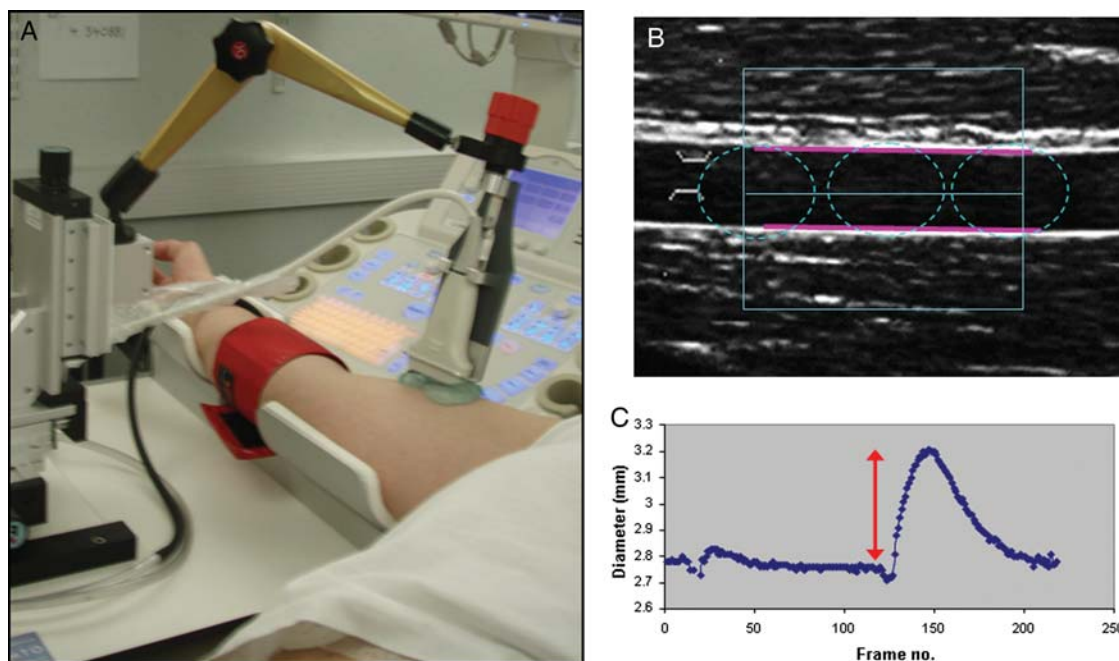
Set up for flow-mediated dilatation. (A) Recommended positioning of the sphygmomanometer cuff and use of the ultrasound probe holder. (B) Placement of the region of interest box using the edge detection analysis software for flow-mediated dilatation analysis. (C) Output generated by edge detection software that permits assessment of the vasodilatory response.
